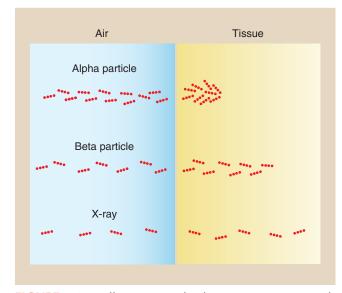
Different types of radiation ionize matter with different degrees of efficiency. Alpha particles represent highly ionizing radiation with a very short range in matter. Beta particles do not ionize so readily and have a longer range. X-rays have a low ionization rate and a very long range.
